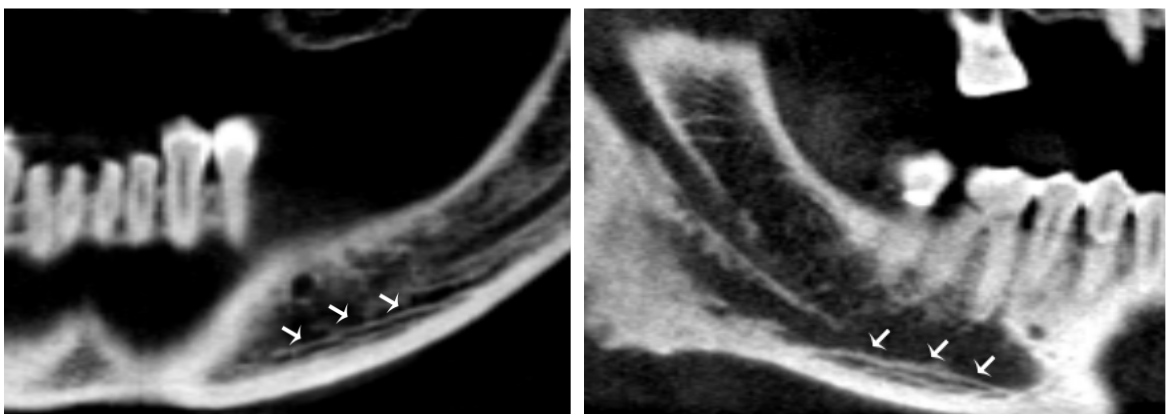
Bifid mandibular canal (White arrow) – panoramic view of CBCT image improved with SimPlant software.
